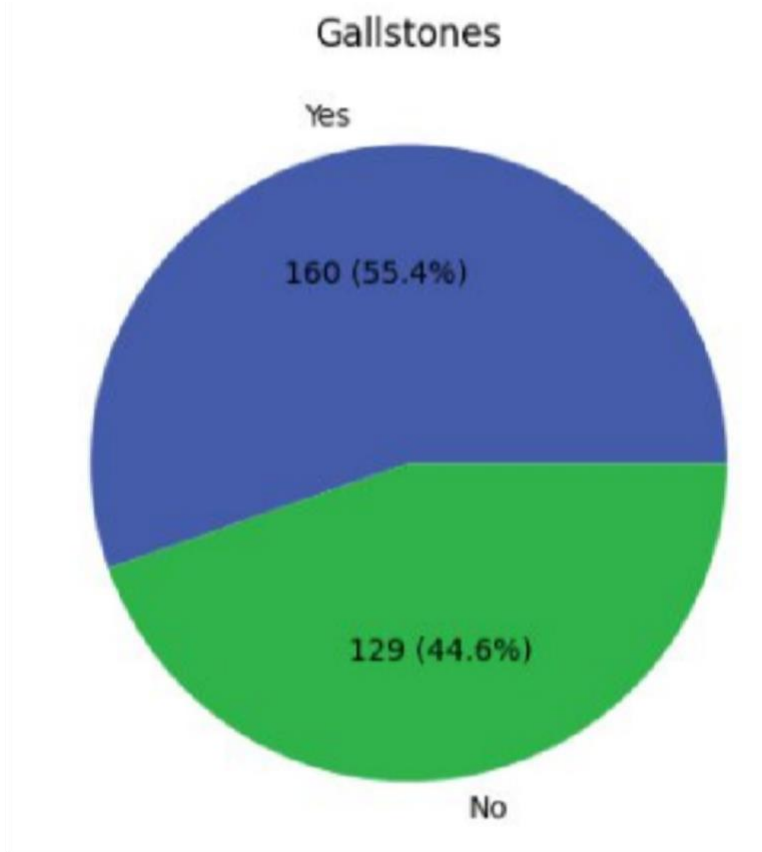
3.5 Gallstone on Ultrasound
